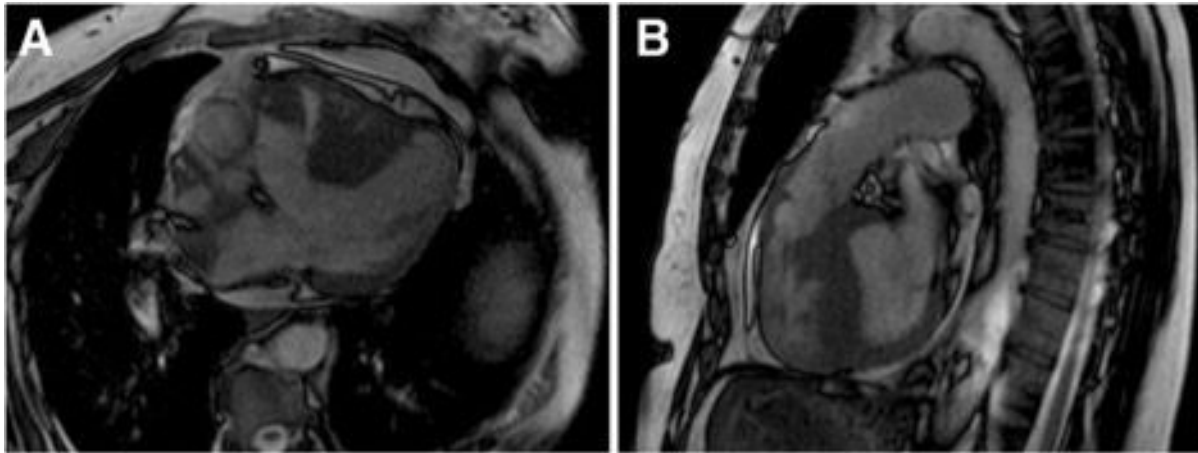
Cardiac magnetic resonance imaging revealing condition of tetralogy of Fallot. “A: Ventricular septal defect and overriding aorta over the septum. B: Right ventricular hypertrophy and subpulmonary stenosis.”¹
